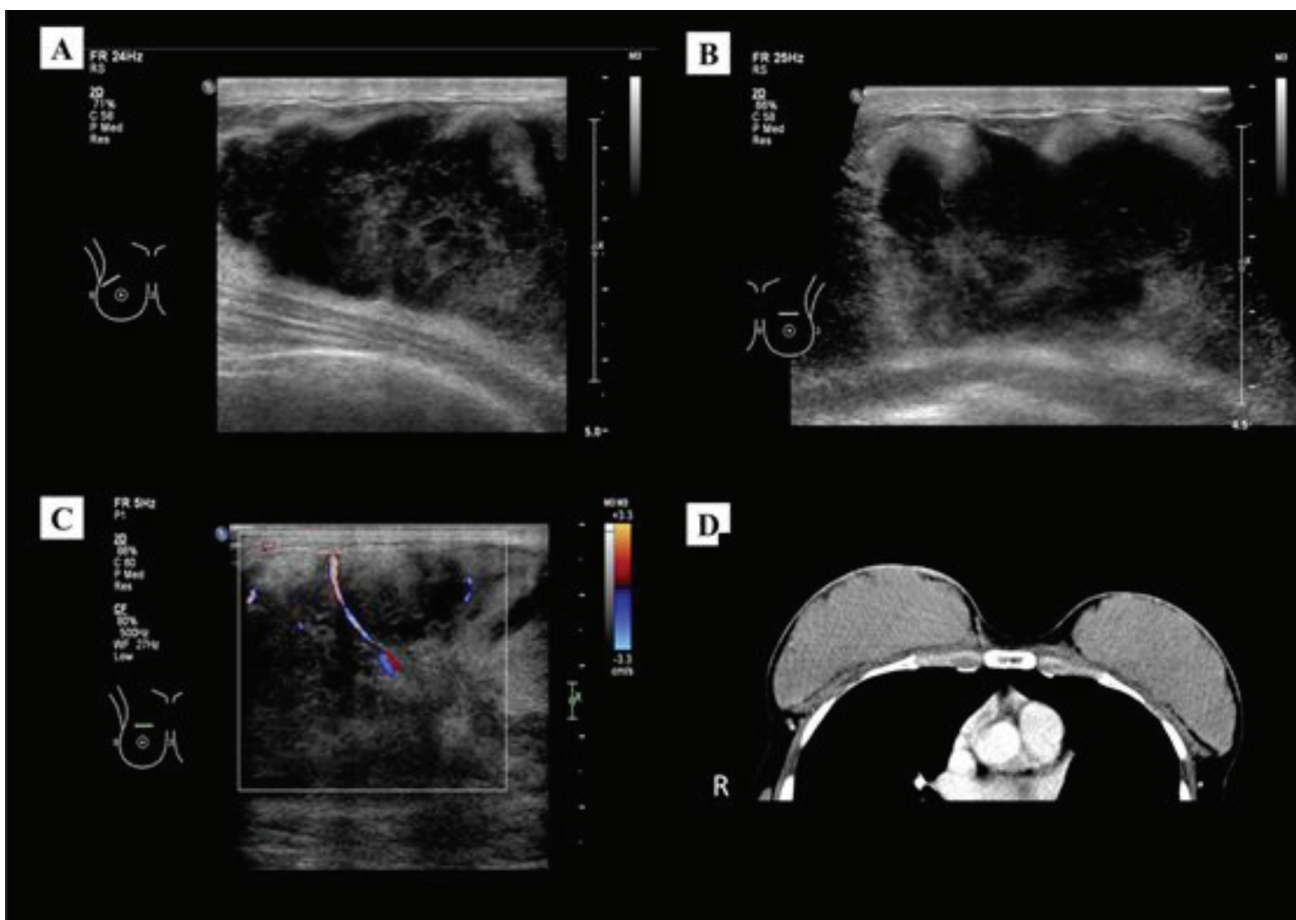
Ultrasound of both breasts (A & B) demonstrated ill-defined heterogeneous hypoechoic masses that occupied the entire breasts, but were predominantly located in the upper quadrants. Color Doppler examination (C) showed increased vascularity. Contrast-enhanced CT (D) demonstrated heterogeneously enhancing lobulated masses that occupied the entire breasts.
